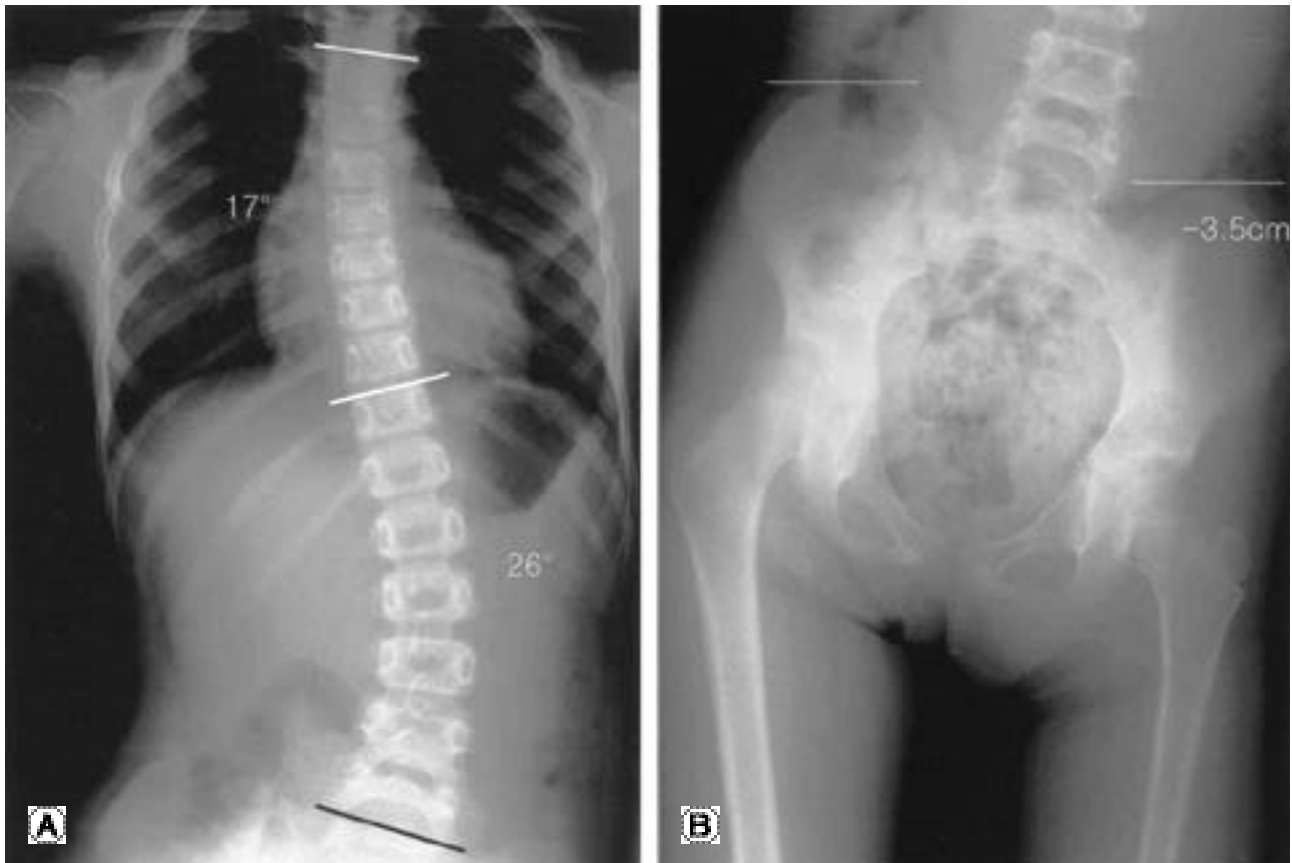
Pre-management radiograph of a 7 year-old girl. (A) showing 26° lumbar curve and 17° compensatory thoracic curve. (B) pelvic obliquity in standing pelvis AP view; left pelvis was 3.5cm lower than right side before application of shoe lift.
